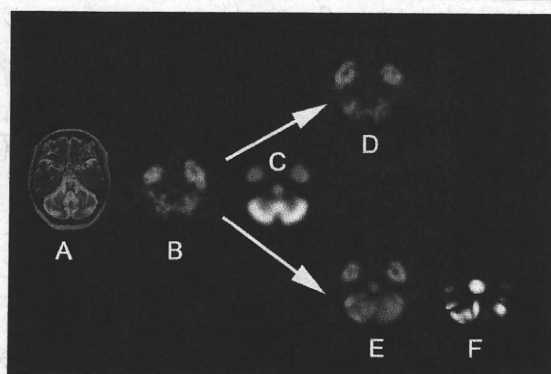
Procedure of tensor-based morphometry using brain SPECT. First, an original SPECT image (A) is linearly transformed to the Talairach space. Subsequent non-linear spatial normalization using the high-dimension-warping algorithm deforms a linearly standardized brain (B) to match it to a  $^{99m}\text{Tc}$ -ECD template (C). This step generates a high-dimensionally warped SPECT image (D) and a parametric image of Jacobian determinants (E) indicating a local volume change relative to the template brain. Then the natural logarithm of this parametric image (F) is separated into negative log J (G) and positive log J maps (H) representing contraction and expansion respectively. A conventionally warped SPECT image is also shown (I).
